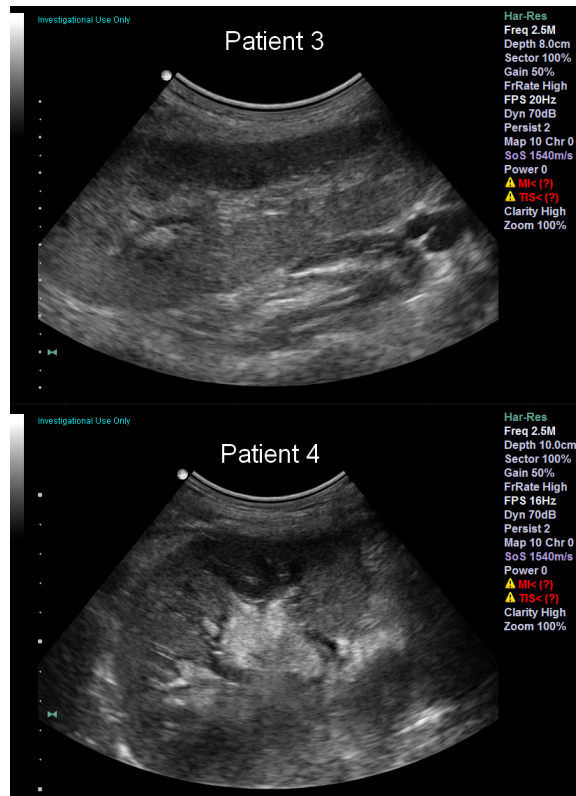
Two example ultrasound images of the transplant kidneys, long axis views. Top: Patient 3. Bottom: Patient 4.
